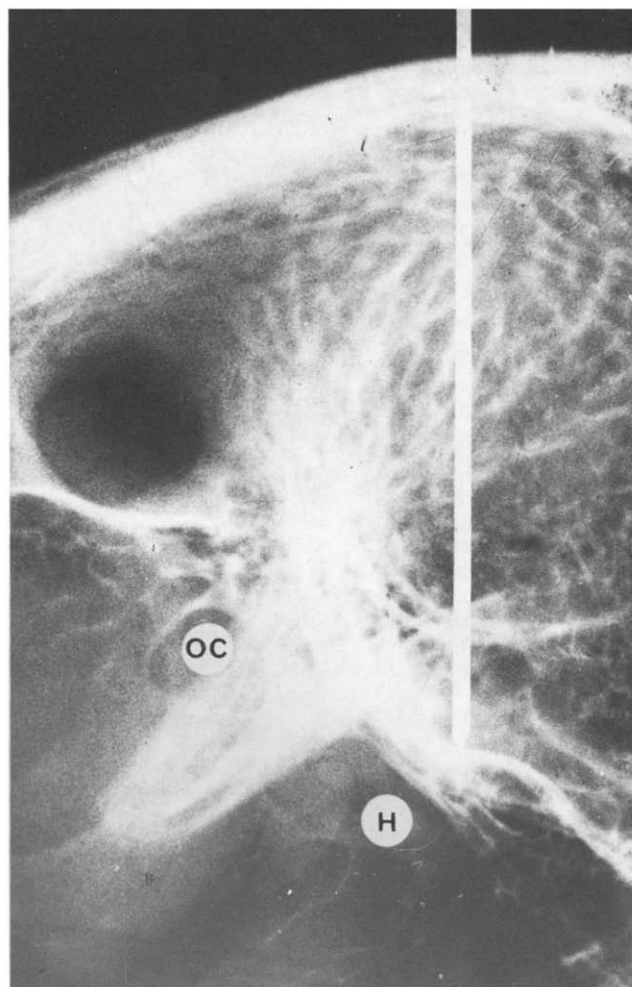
Sagittal roentgenogram of a goose head, with a needle inserted into the VMH area. OC = optic chiasma; H = hypophysis (x6).
